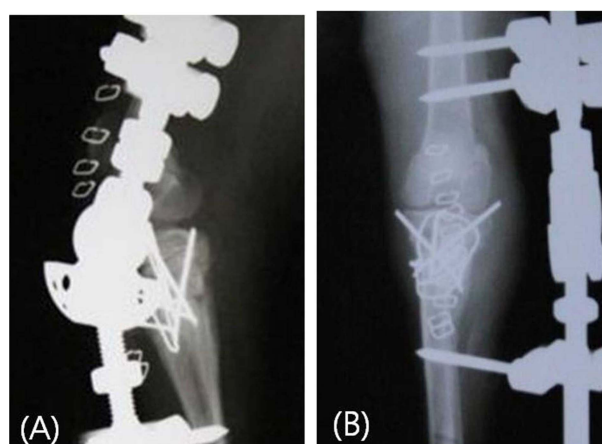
Immediate post-operative radiographic view showing that the fracture site was adequately reconstructed and that the hinged transarticular external skeletal fixator (HTAESF) was well applied. Mediolateral view (A), craniocaudal view (B).
